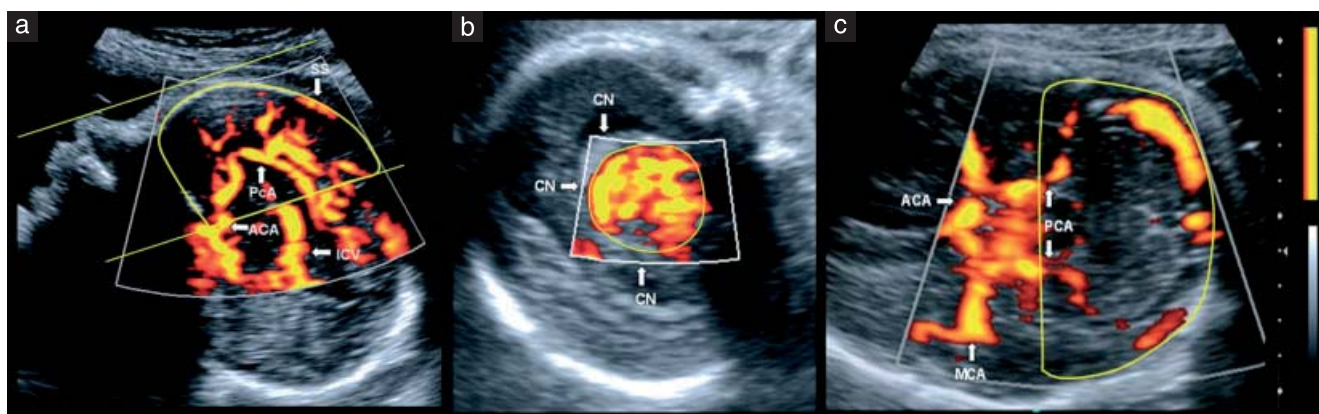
Power Doppler ultrasound images showing the regions of interest of the fetal brain, from where cerebral blood perfusion was estimated in the frontal area (a), basal ganglia (b) and posterior brain (c). ACA, anterior cerebral artery; CN, caudate nucleus; ICV, internal cerebral vein; MCA, middle cerebral artery; PCA, posterior cerebral artery; SS, sagittal sinus.
